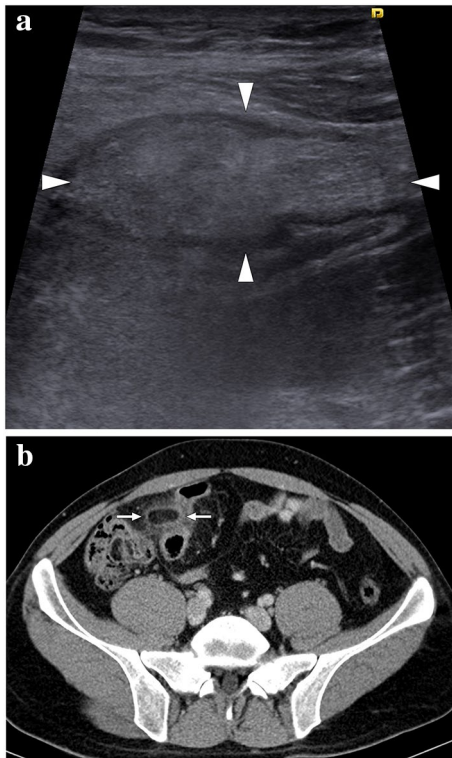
A 23-year-old male patient presented with well-localized, severe right lower quadrant pain. a Grayscale US showed a non-compressible, oval-shaped, hyperechoic lesion (arrowheads) surrounded by a hypoechoic rim and increased echogenicity in the adjacent fat planes. b Axial plane postcontrast abdominal CT image demonstrated an ovoid lesion with internal fat density, peripheral high-density rim, and perilesional inflammatory stranding (arrows) adjacent to the sigmoid colon. Imaging findings were found to be compatible with epiploic appendagitis. The patient responded well to the supportive medical treatment
